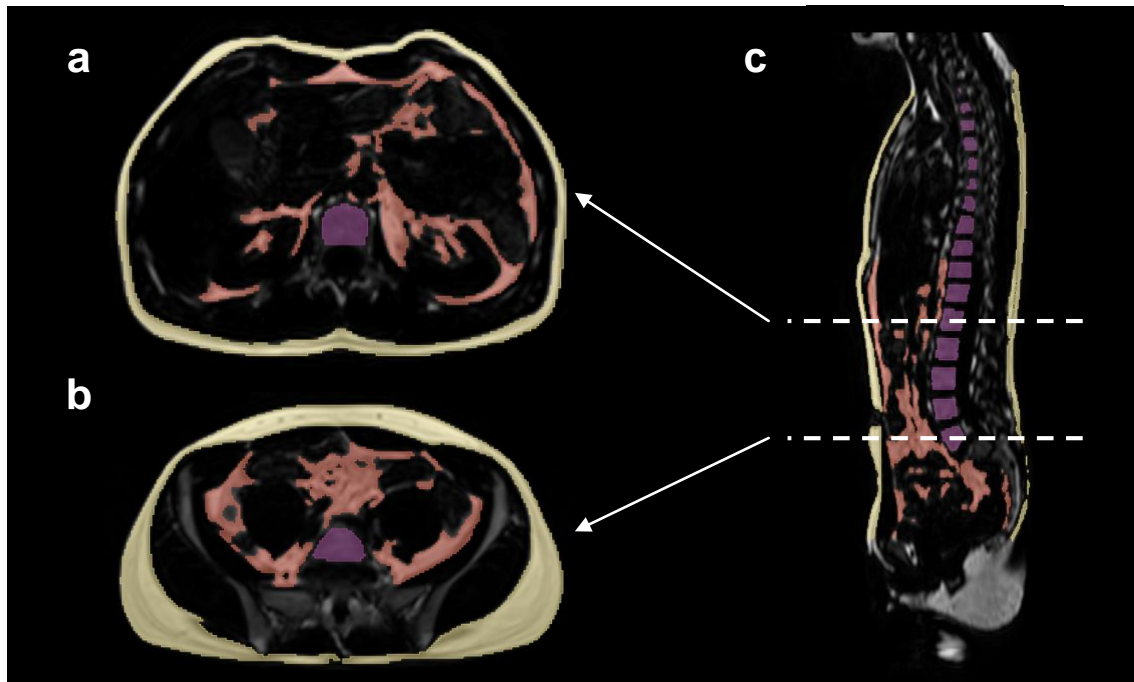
Localization of adipose tissue compartments. Differentiation of visceral (red) and subcutaneous (yellow) adipose tissue in the trunk at the level of lumbar vertebrae L1 (a) and L5 (b) by semantic image segmentation on a fat-selective Dixon MRI of a 31-year-old man. Intraabdominal and intrapelvic adipose tissue depots are combined to visceral adipose tissue. Localization of the spine (purple) is used to match axial slices to distinct anatomical locations.
